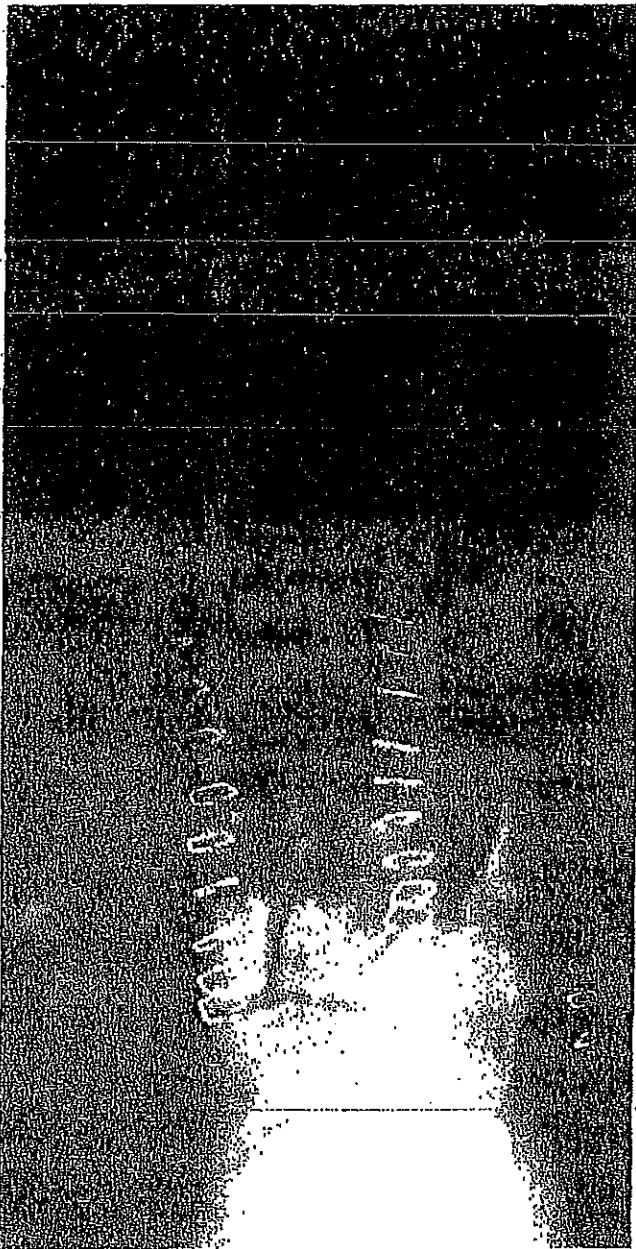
Postoperative anteroposterior radiograph of the left foot. The closed tarsometatarsal joint fracture dislocation was treated with interfragmentary screw fixation with poly-L-lactic acid screws.
